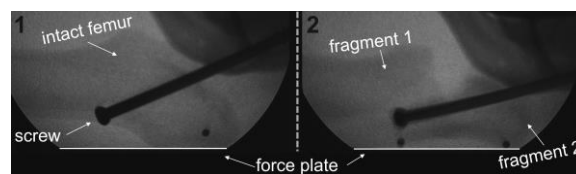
X-ray video frames showing fracture of a surrogate femur (A-P view) implanted with an orthopaedic screw and steel markers.
